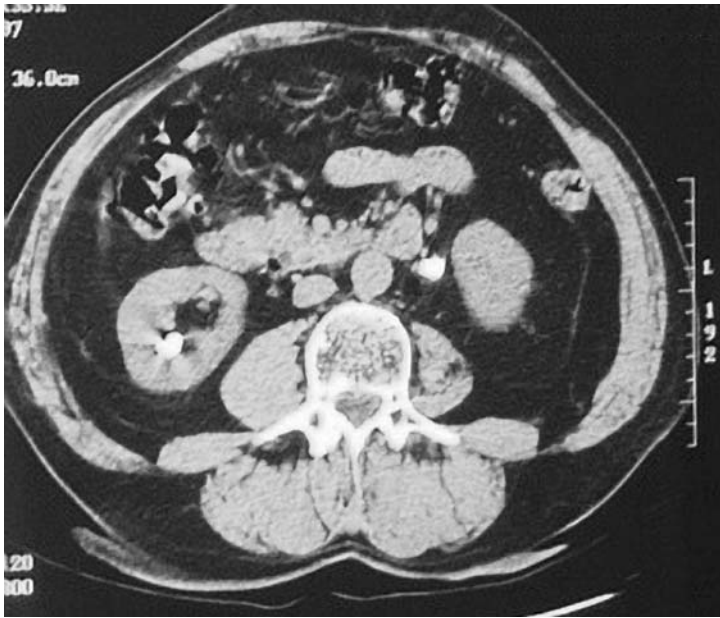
A computed tomography (CT) urogram (CTU). Stones 'light' up as very radiodense structures. There is one in the left ureter and one in the right kidney.
